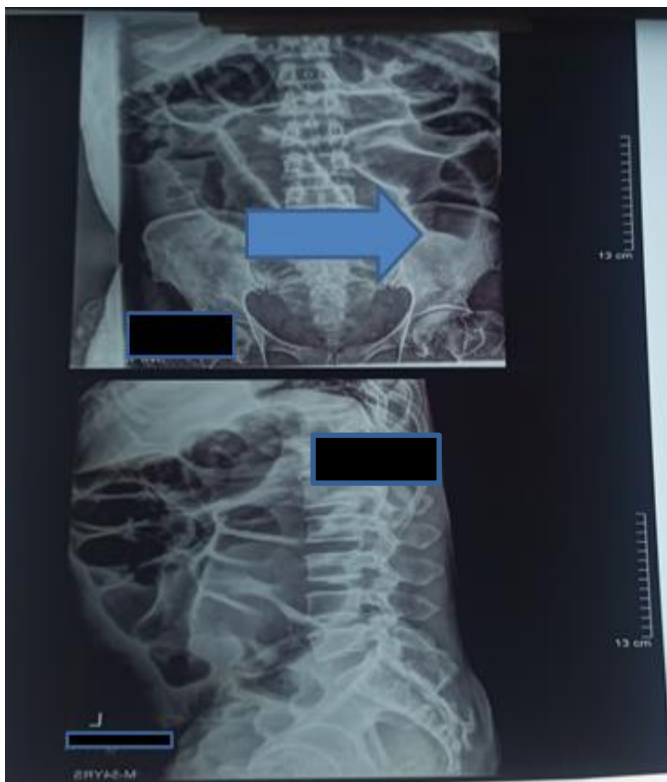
plain abdominal radiograph of the patient showing distended bowel loops and abrupt cut off of bowel gas
